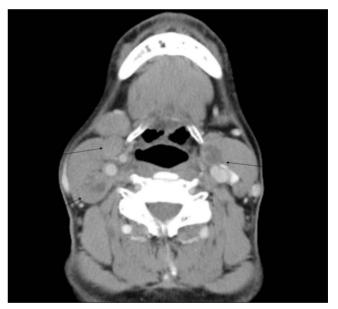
Axial contrast-enhanced CT showing bilateral level 2/3 nodes (black arrows) in patient with NPC.
